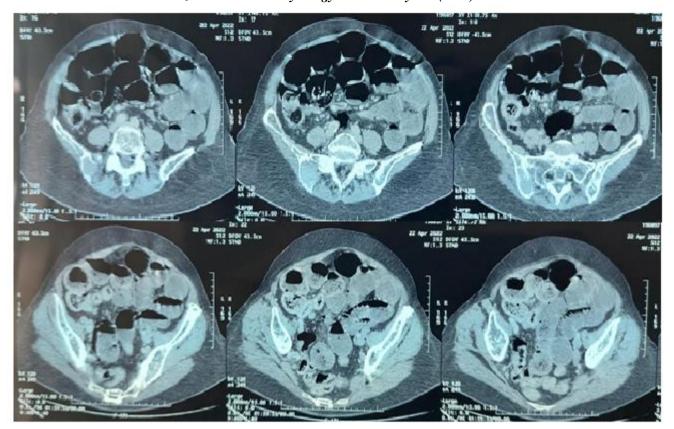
Abdominal CT in axial section after injection of the contrast product
